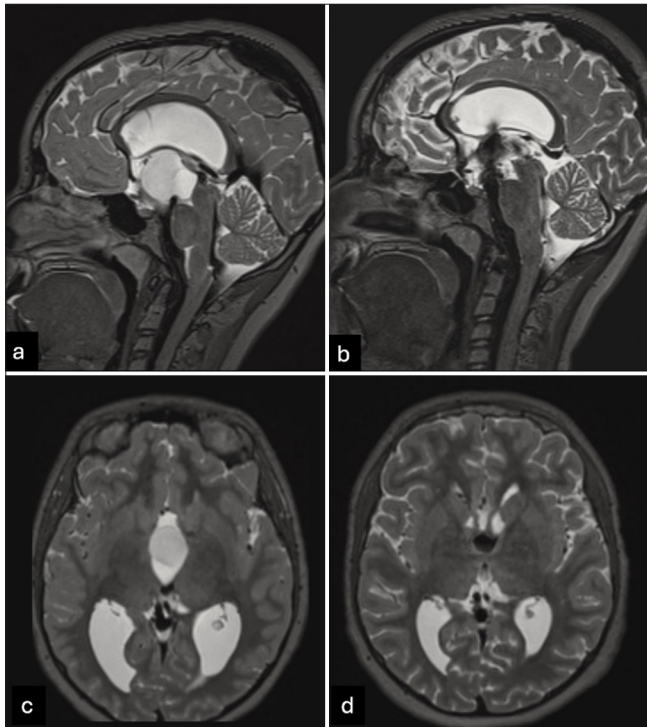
(a) Preoperative sagittal T2-weighted magnetic resonance (MR) imaging obtained in the patient demonstrating a cyst that is isointense to cerebrospinal fluid within the third ventricle, causing dilation of the lateral ventricles. (b) Postoperative sagittal T2-weighted MR imaging demonstrating cyst resolution. (c) Axial preoperative view. (d) Axial postoperative view.
